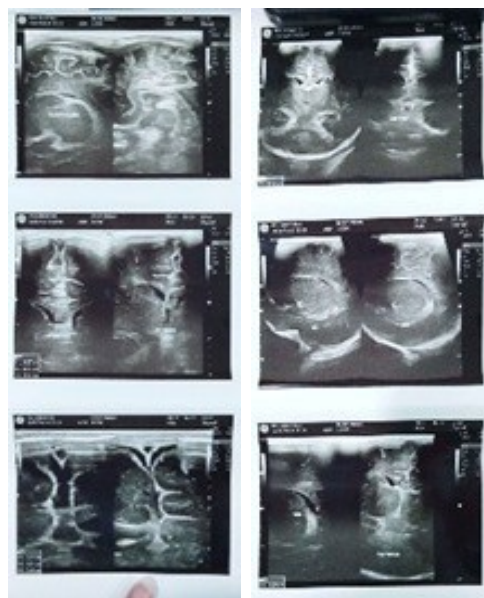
Cranial ultrasonography in Case 1 revealed no structural abnormalities
